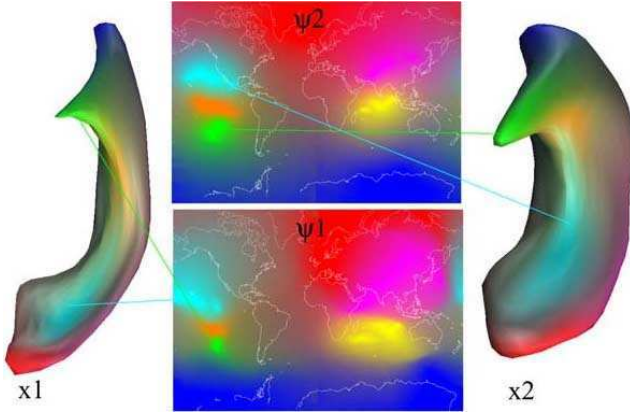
Example of object correspondence between two different shapes  $x_1$  and  $x_2$  (two lateral ventricles obtained from brain MRI), and their corresponding spherical maps  $\Psi_1$  and  $\Psi_2$  (with world contours superimposed to convey the notion of a spherical map). Note that corresponding regions will differ on the map not only in position, but also in size and shape, which is why a non-rigid parameter space warp  $\Delta\Psi$  must be applied to the map to establish congruence. NOTE: A color version of this book chapter is available from the authors.
